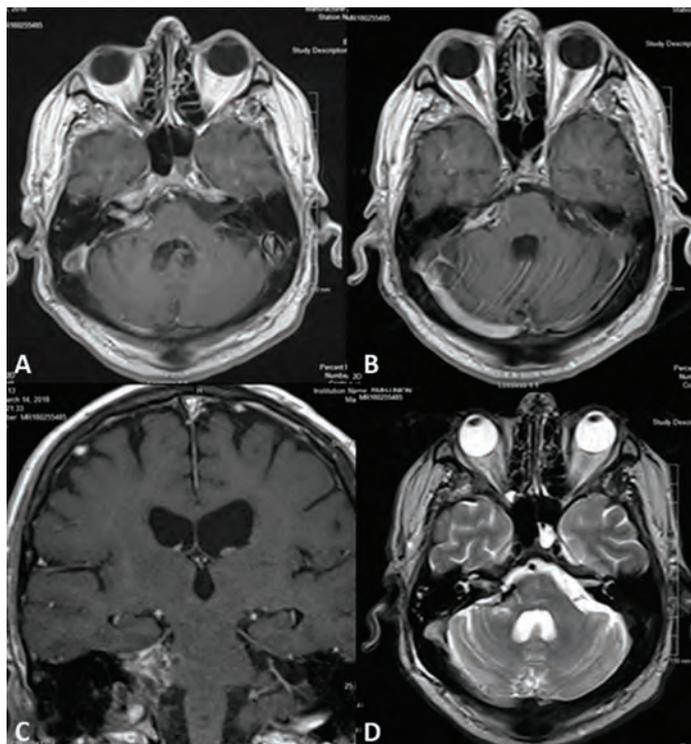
Postoperative head MRI at 3-month follow up shows subtotal resection of the tumor. (A) Post-contrast MRI of the head axial T1-weighted image in the level of the internal meatus and (B) axial T1-weighted image in the level of apex of the pyramid, and (C) coronal T1-weighted and (D) axial T2-weighted MRIs show subtotal resection of the tumor without brain stem compression (45).
